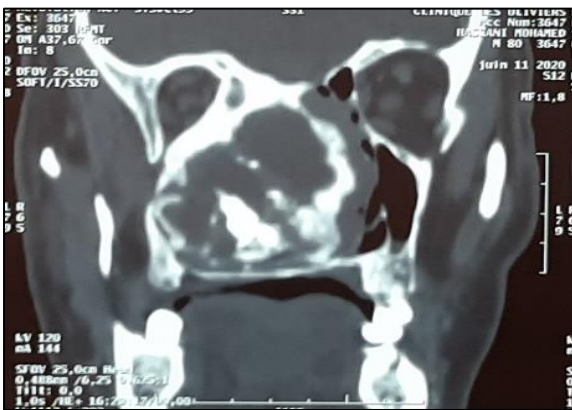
Computed tomography scan showed the disease expanding to right orbit.
